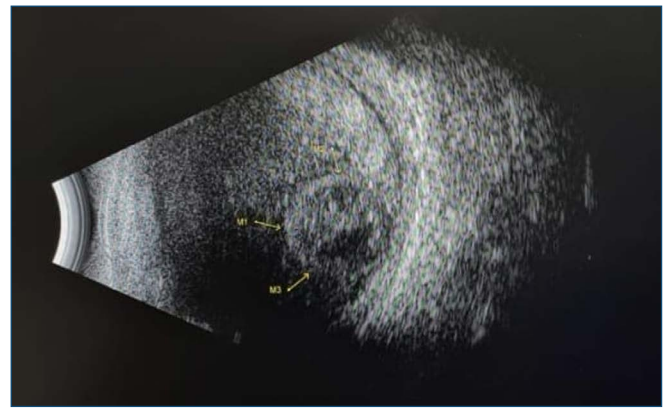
Ocular B-Scan ultrasonography showing a cystic lesion compatible with ocular cysticercosis.
